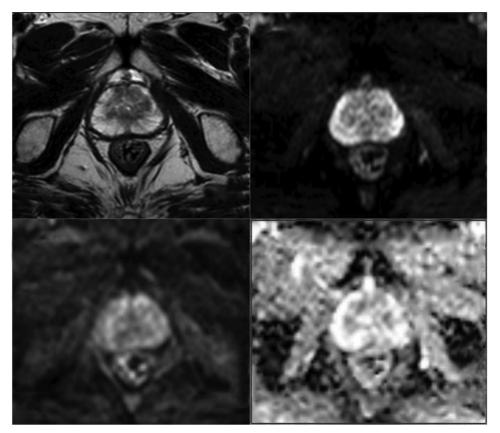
Uniform high signal intensity T2 and low signal intensity on high b-values DWI and high signal on ADC-PIRADS 1.
